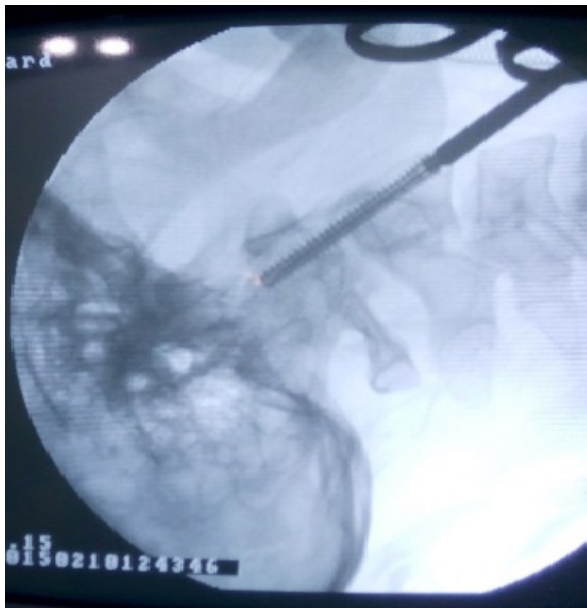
Perioperatively obtained lateral plain radiographs revealed on correct placement of a single anterior odontoid screw across the odontoid fracture site.
